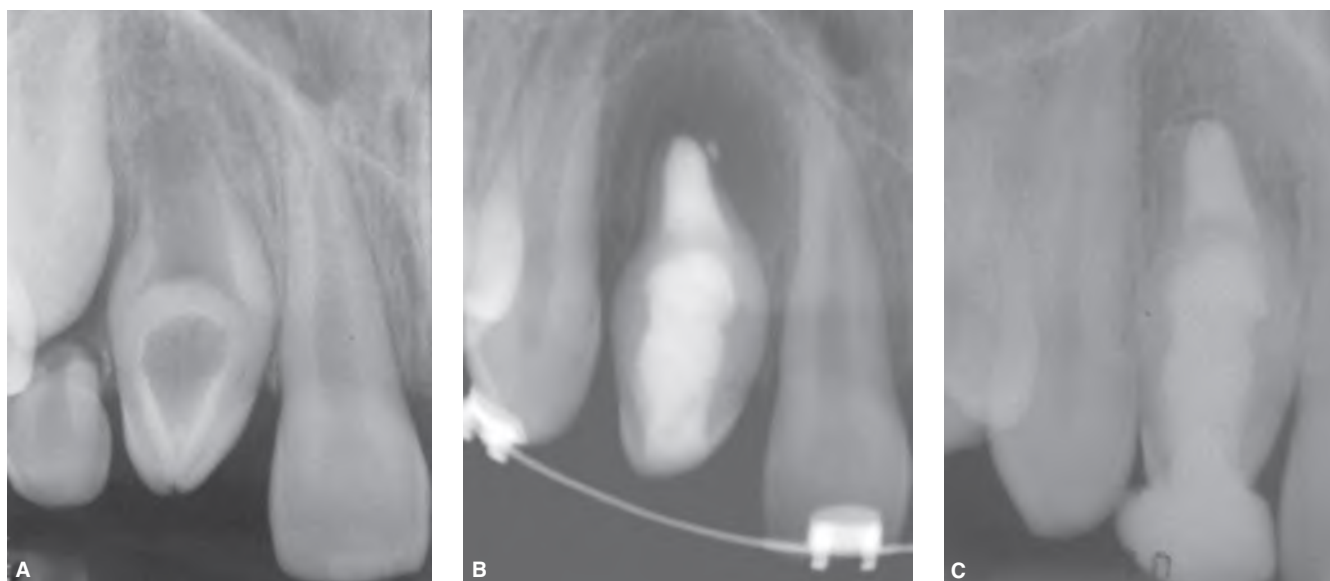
Dens invaginatus variant in a symptomatic maxillary left lateral incisor with necrotic pulp of a 9-year-old male. A. Periapical radiograph taken three years prior to endodontic treatment. B. Postoperative radiograph at age 12 showing large periapical radiolucency associated with the tooth. The root canal system was obturated with MTA and bonded core was placed. C. 11-year recall radiograph showing resolution of the periapical radiolucency. (Courtesy of Dr. Mark Olesen, North Vancouver, BC, Canada.)
